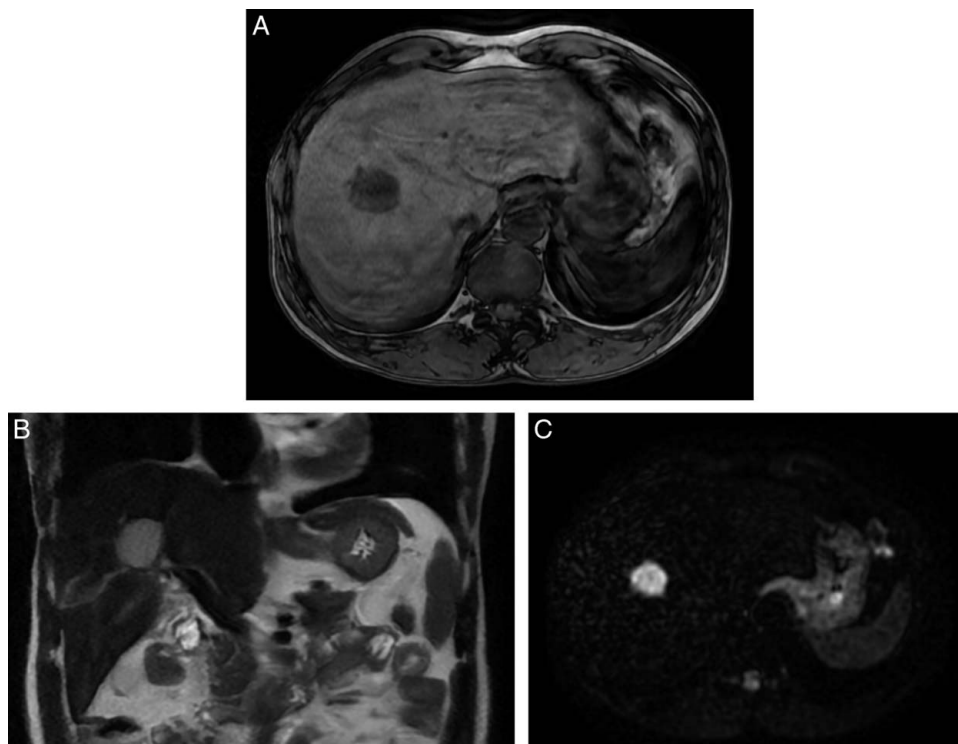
MRI revealed a 26 × 28 mm mass in the subsegment VIII, characterized by compact edges, decreased signal on T1 sequence (A), slightly increased signal on T2 sequence (B) and robust increased signal on diffusion-weighted imaging sequence (C).
